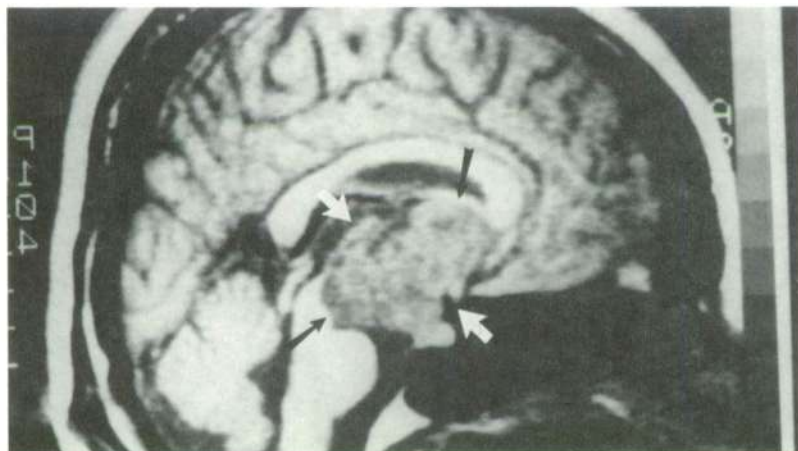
Magnetic resonant image (MRI scan) of the head as seen from the side. A large tumor (arrow) is seen occupying the space above the pituitary gland at the base of the brain.
